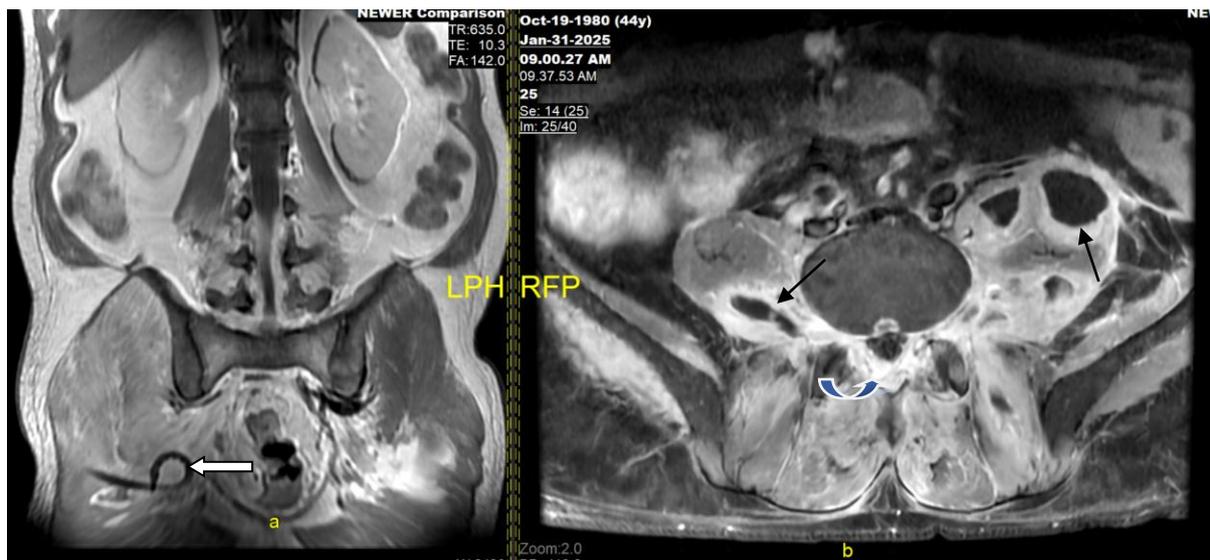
Follow up MRI performed after 1 month of antimicrobial therapy, showing resolution of gluteal abscess with pigtail catheter in situ [thick long white arrow] in the coronal post contrast images (Fig IIIA). Axial post contrast image (Fig IIIB) also showing significant resolution of epidural abscess and thick meningeitis [curved arrow], bilateral psoas and left paraspinal abscess [thin black arrow].
